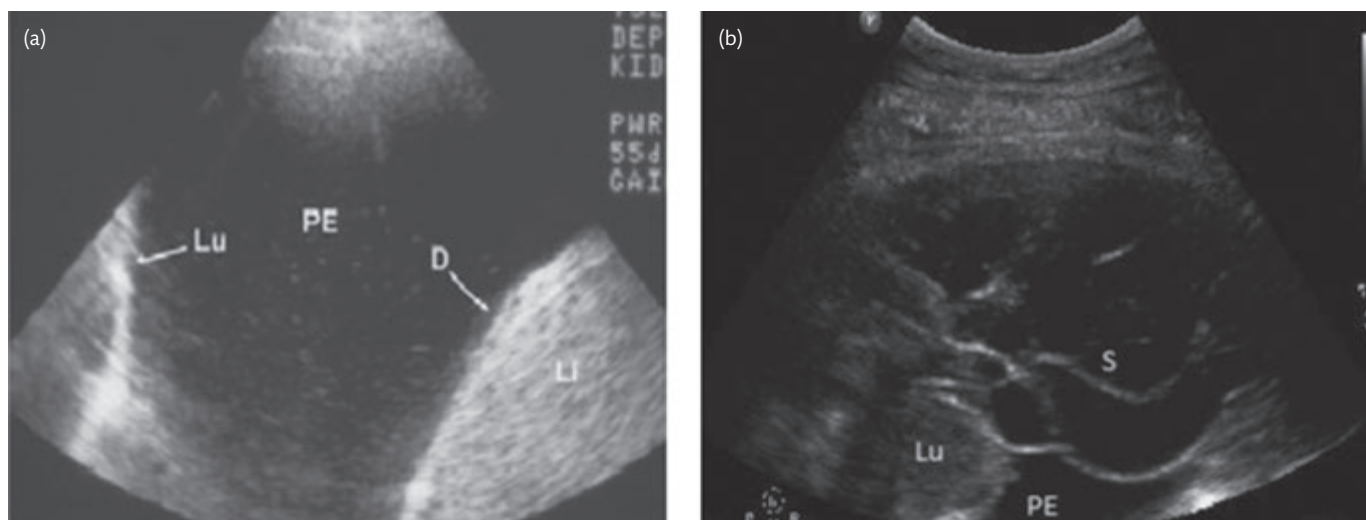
The appearances of a free-flowing right pleural effusion on ultrasound (a) the large echo free area is the pleural effusion (PE). The diaphragm (D), liver (Li) and lung (Lu) are shown. Fig. (b) shows multiple septae (S) in a complicated parapneumonic effusion.
